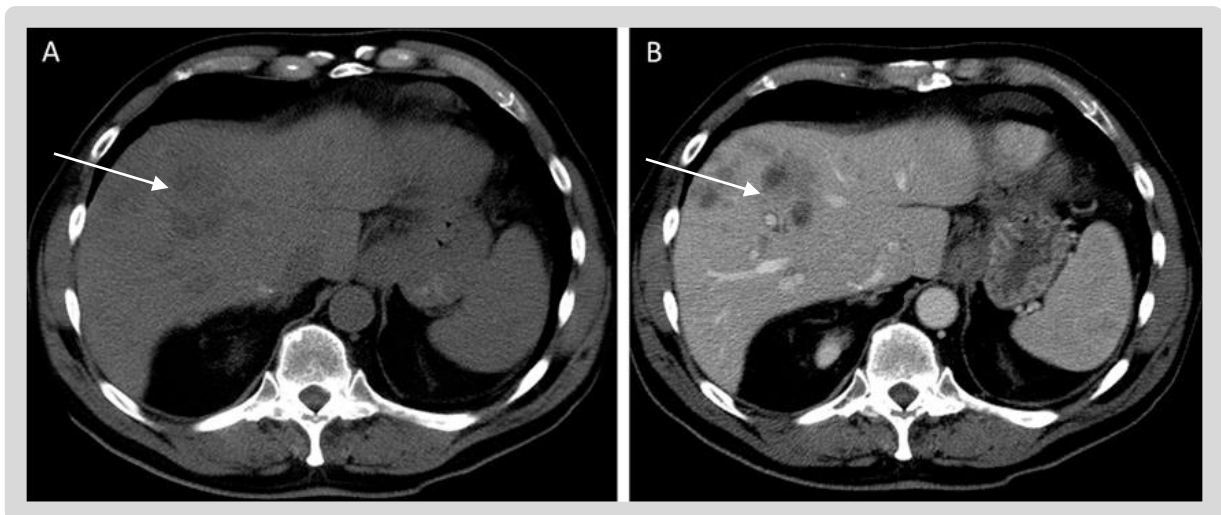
CT image of the abdomen. A) Non-contrast CT showing ill-defined lesions in the right lobe of the liver. B) Contrast-enhanced CT performed on the same patient. It appears that lesions are better assessed in the images post-contrast. (Image sourced from Balasubramanya et al. 2016).
